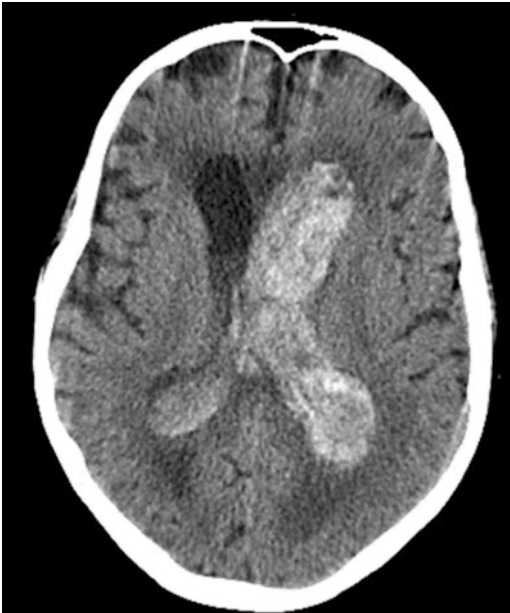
Axial brain CT in a COVID-19 patient with acute altered mental status shows extensive intraventricular hemorrhage and acute hydrocephalus. Periventricular white matter hypodensity is compatible with subependymal interstitial edema secondary to acute hydrocephalus. The patient was not on ECMO
